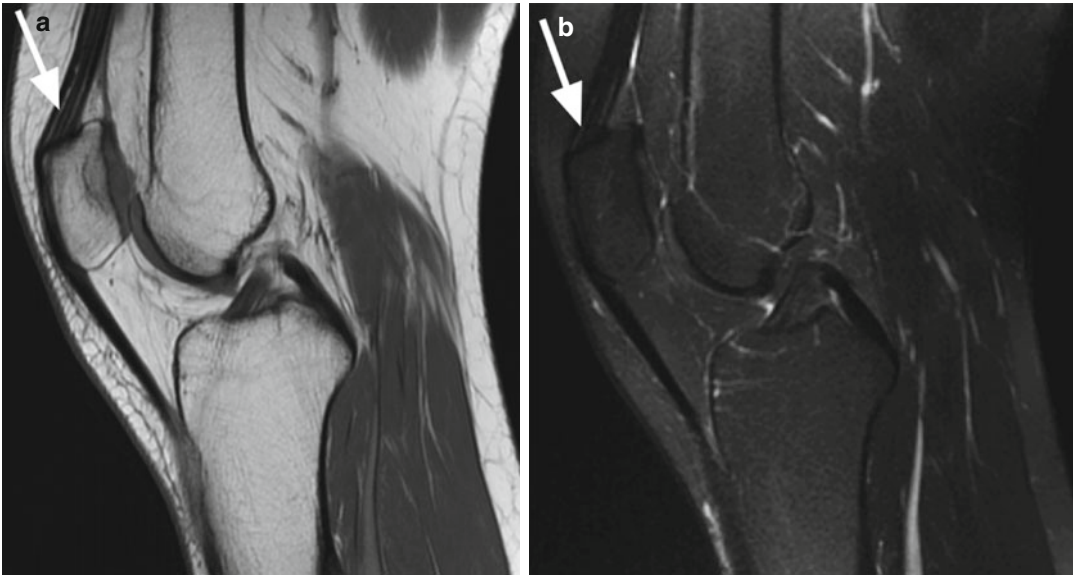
Normal appearance of the quadriceps tendon in a 33 year old female. Sagittal proton-density (PD) image (a) and sagittal T2-weighted fat-suppressed image (b) show the three-layer appearance of the tendon (arrows).
